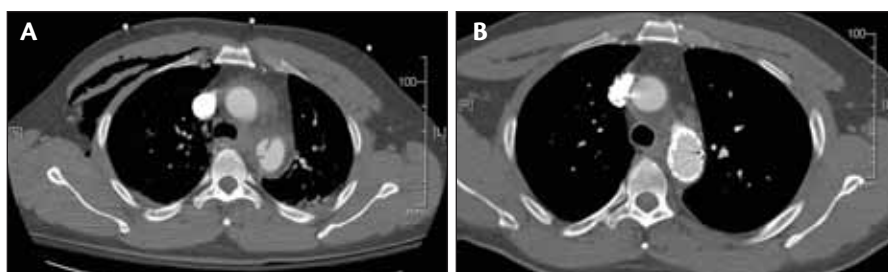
A CT scan with intravenous contrast. Preprocedural image shows a blunt aortic injury with associated mediastinal and periaortic hematoma, as well as a right chest wall contusion (A). Postprocedural image shows endovascular repair with the endograft in place, sealing the injured segment of the descending thoracic aorta (B).
